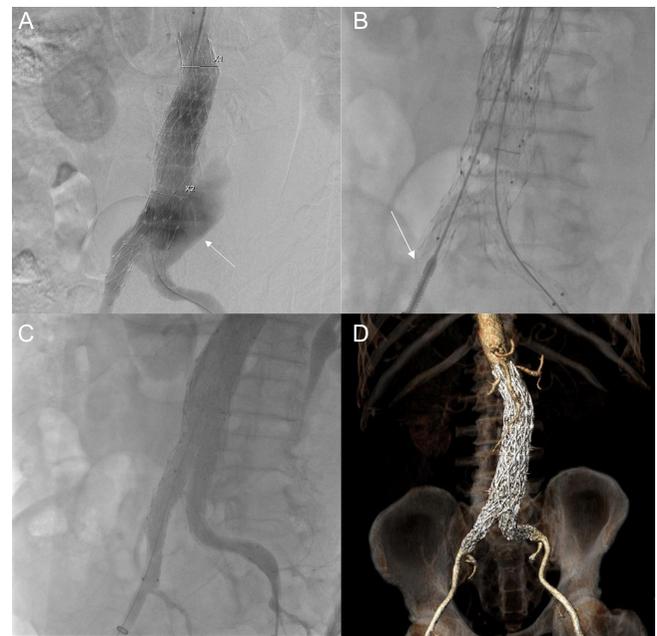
A-D. EVAR procedure angiograms. (A) Aortography of abdominal aorta (arrow: distal abdominal aorta/post-EVAR rupture and extravasation) (B) aortography of distal abdominal aorta and bifurcation (arrow: stent insertion via right femoral artery); (C) control aortography showing no extravasation; (D) control aortography 3D reconstruction with computed tomography angiography showing no extravasation.
